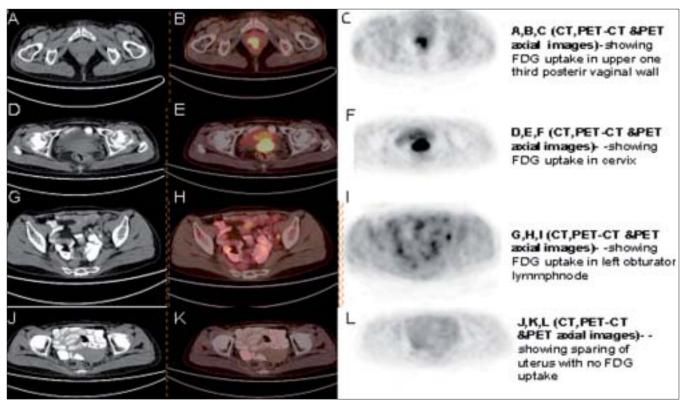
PET/CT images showing uptake in the primary and pelvic lymph nodes
